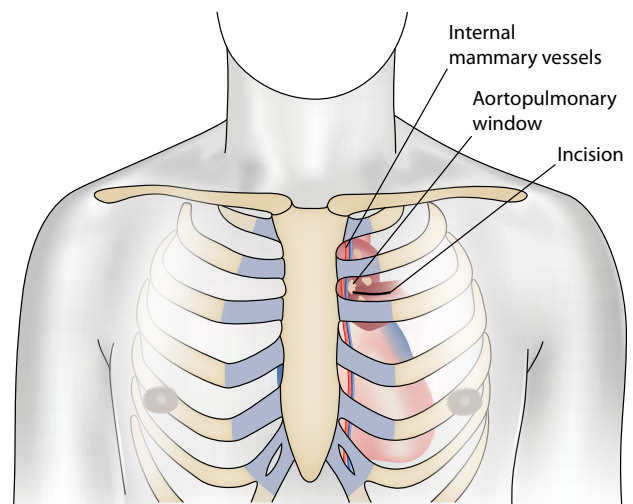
Landmarks for approach to parasternal mediastinotomy. (From Sugarbaker DJ et al. *Adult Chest Surg*, 2nd ed. www.accesssurgery.com. Copyright © McGraw-Hill Education. All rights reserved.)
